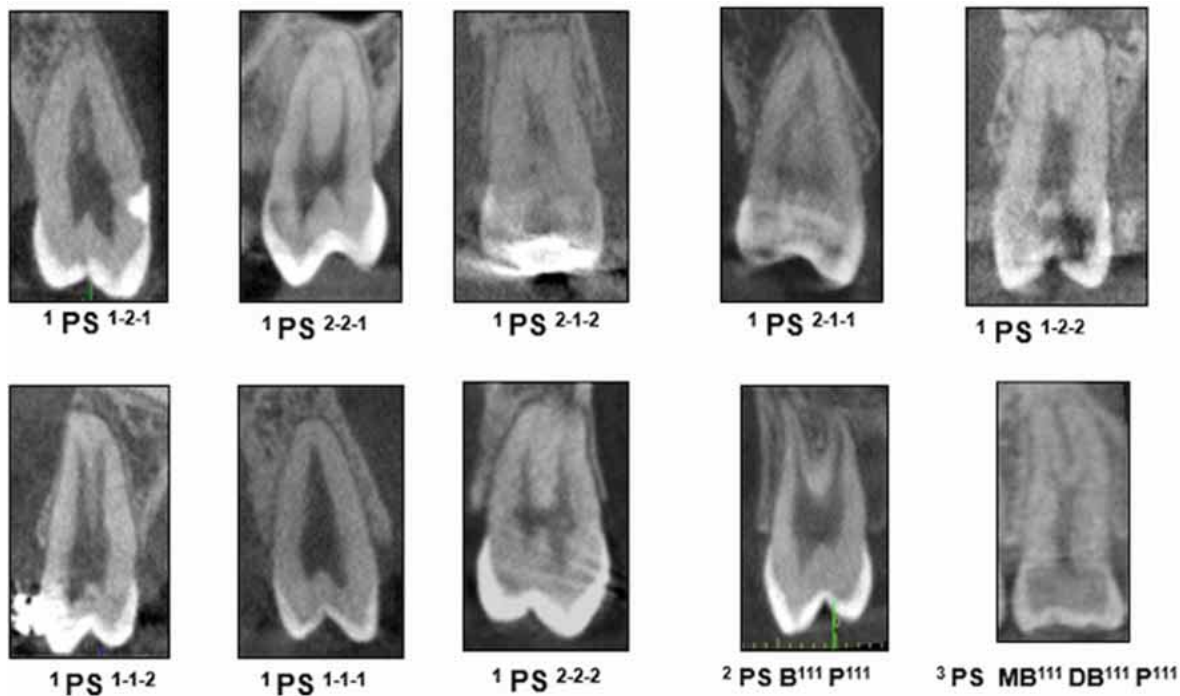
CBCT images of the different configurations found in maxillary premolars, according to Ahmed's classification.
